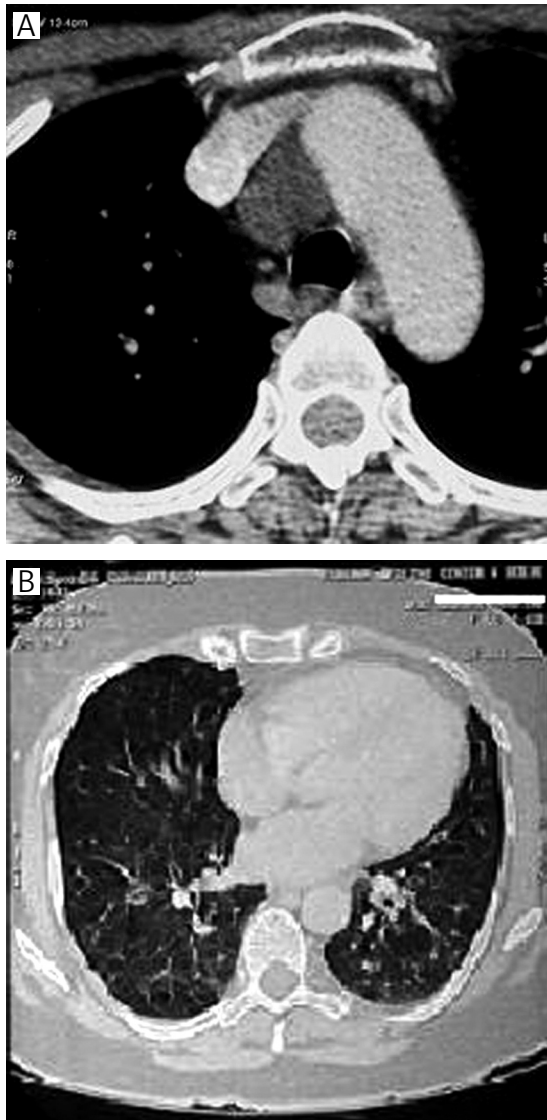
Contrast-enhanced computed tomography of the chest revealed multiple necrotic lymph nodes in the paratracheal region
